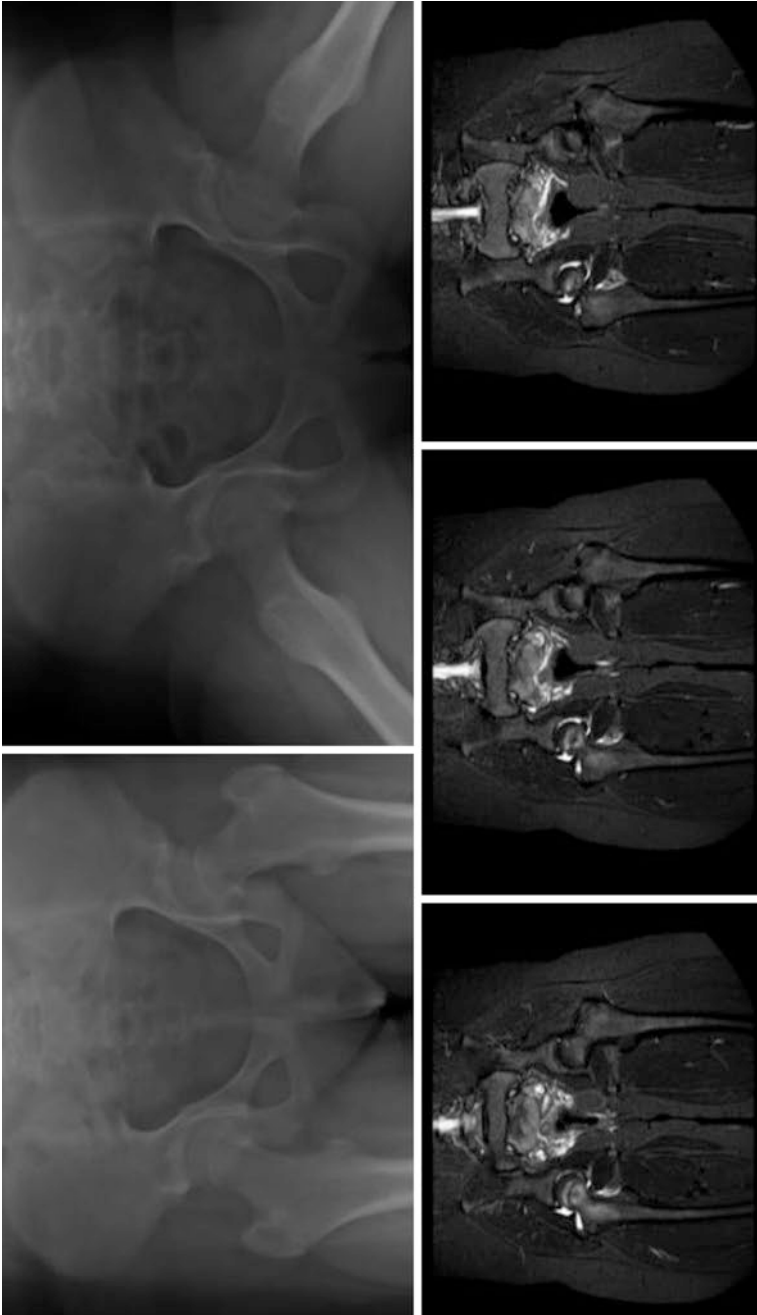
Subtle SCFE. MRI scan confirmed the diagnosis showing high signal in the peri-physal area of the right hip
